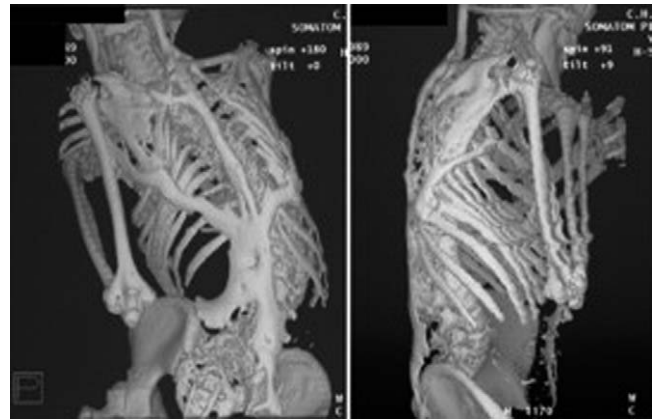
Reconstructed computed tomography scan of a 12-year-old child with fibrodysplasia ossificans progressiva. Reprinted from Glaser DL, Economides AN, Wang L, *et al*. In vivo somatic cell gene transfer of an engineered Noggin mutein prevents BMP-4-induced heterotopic ossification. *J Bone Joint Surg* 2003;85-A:2332. Reproduced with permission of the *Journal of Bone and Joint Surgery*.
